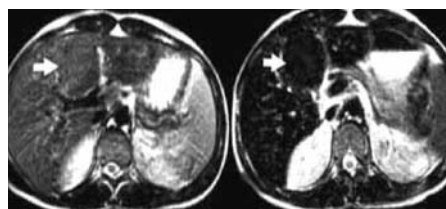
Precontrast and ferumoxides-enhanced T2-weighted SE (TR 2500, TE 80) images. Focal metastatic lesion, arrow, is depicted only on post-ferumoxides images.
